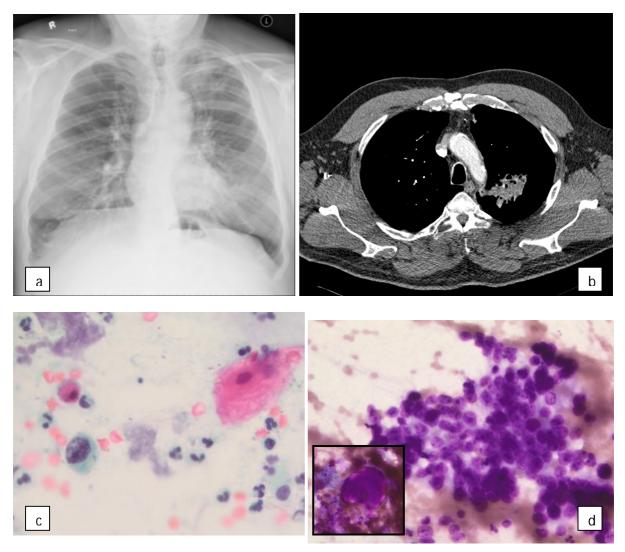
Left hilar mass-nodal-complex with infiltration of the left main and upper lobe bronchus on chest X-ray (a) and CT (b). Sputum – malignant. Sparse, single lying, high N/C ratio cells with irregular chromatin distribution (c). TBNA - Adenosquamous cell carcinoma (predominant adenocarcinoma). Inlay a squamous pearl (d) MGG. CK5 positive in certain cells, BerEP4 positive in majority of cells. (images not included)
